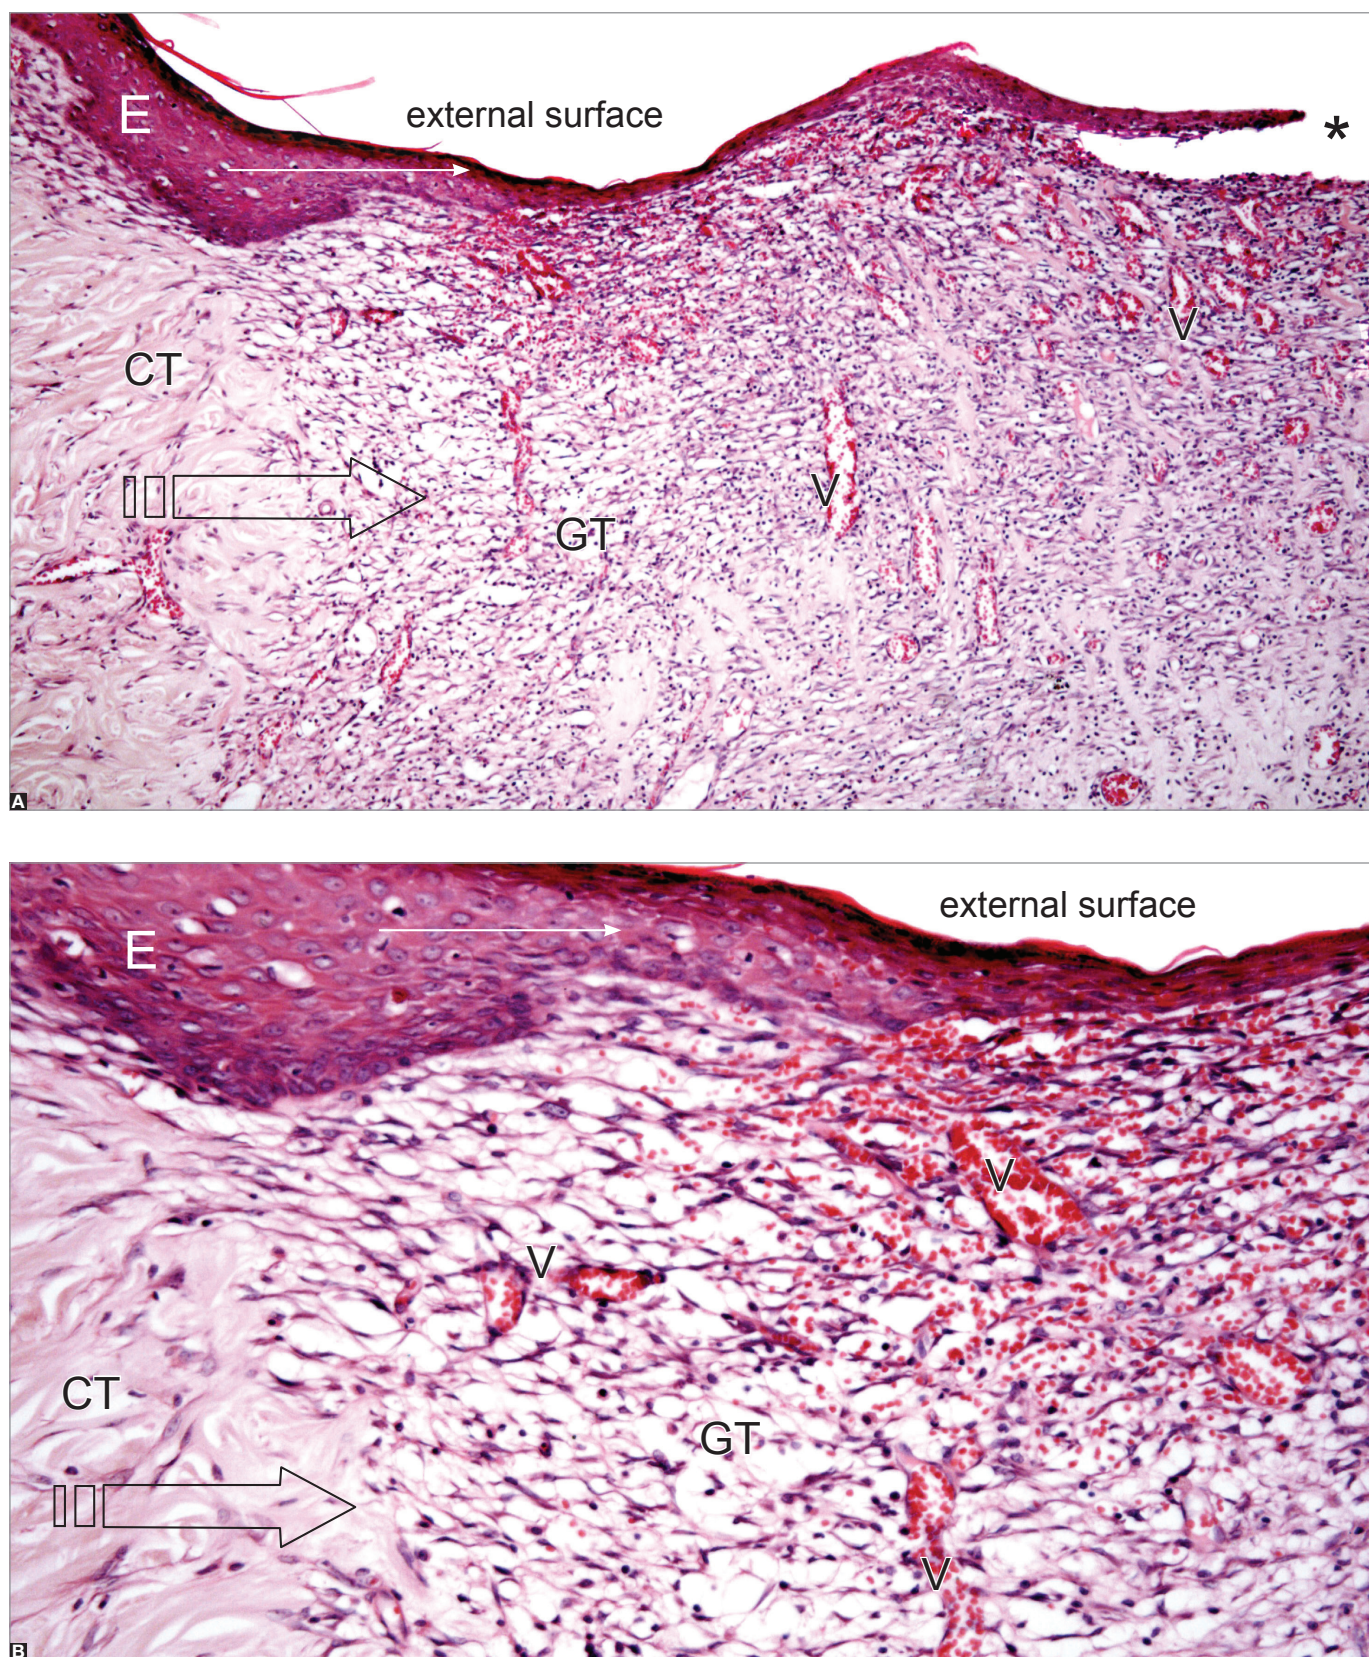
In skin wound with direct exposure of the conjunctive to the exterior, it is observed that in the epithelium (E) regeneration generates strips toward the center (*) from a proliferative burst in the margin of the lesion (smaller arrow). Angiogenesis (V), the migration of cells (greater arrow) of the connective tissue (CT) and inflammatory cells form the granulation tissue (GT), which represents the typical structure of the repair. (A=25X; B=40X; HE).
